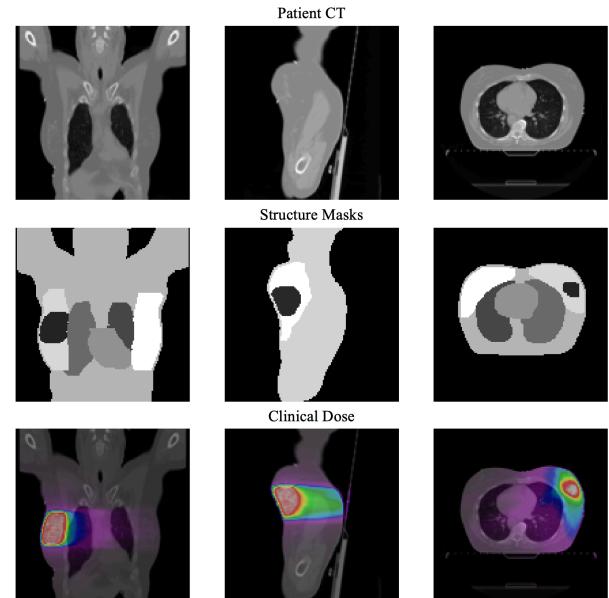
Clinical data representation for APBI modeling: CT, structures, and dose. Example case from the study cohort. Top panel shows the planning CT in treatment position. Middle panel overlays structure masks used as model inputs. Bottom panel displays the clinical plan dose as a color wash normalized to prescription with isodose contours. Images are axial. All masks and dose are resampled to the planning grid, and the set of CT plus masks forms the input channels, with dose serving as the prediction target.
